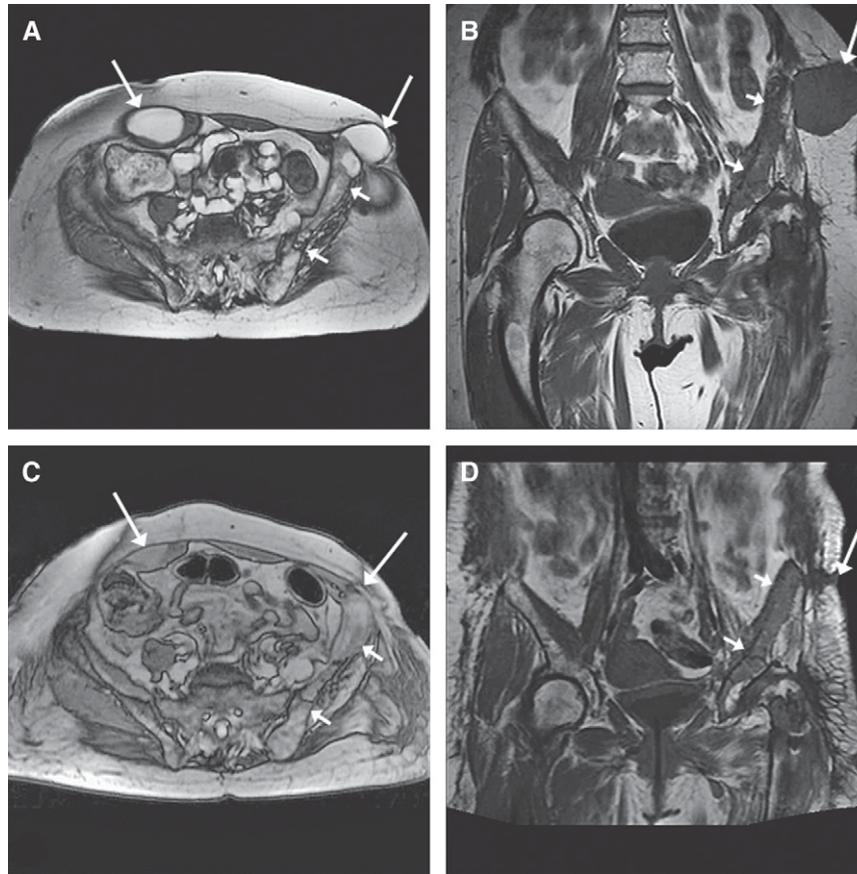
A and B, Magnetic resonance imaging (MRI) scans of the patient showing new multiloculated cysts in the right rectus abdominis muscle and lateral to the left iliac wing (large arrows), together with almost complete replacement of the left hemipelvis with disease (small arrows). C and D, MRI scans showing significant regression of soft tissue cysts in the abdominal wall and lateral to the left iliac wing (large arrows), with stable bony disease (small arrows).
